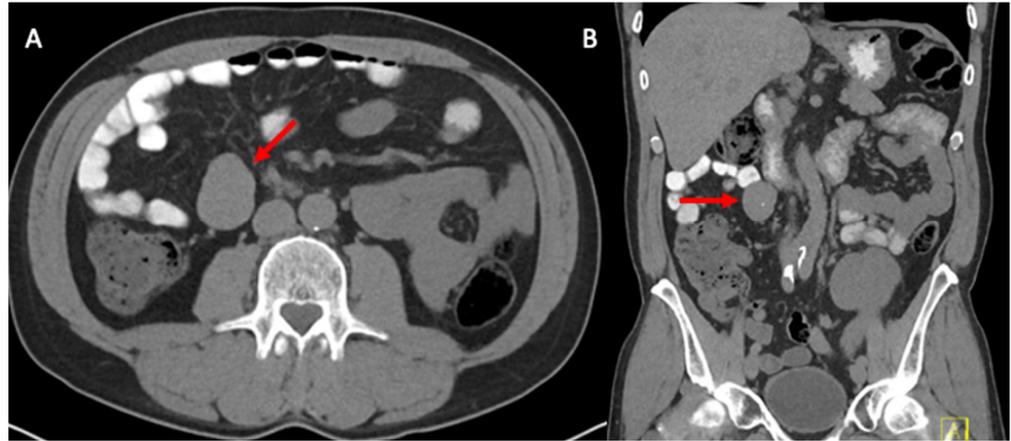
Contrast-enhanced computed tomography of abdomen and pelvis. (A) Axial and (B) coronal images demonstrating a soft-tissue mass located in the right retroperitoneum just lateral to the inferior vena cava (red arrow).
